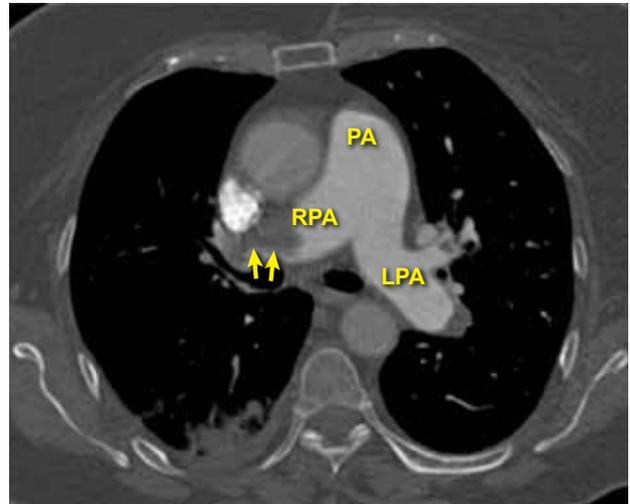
Axial contrast-enhanced CT scan shows enlargement of the main, right, and left pulmonary arteries secondary to pulmonary hypertension, and a filling defect in the right main pulmonary artery (arrows). PA – pulmonary artery; LPA – left pulmonary artery; RPA – right pulmonary artery.
